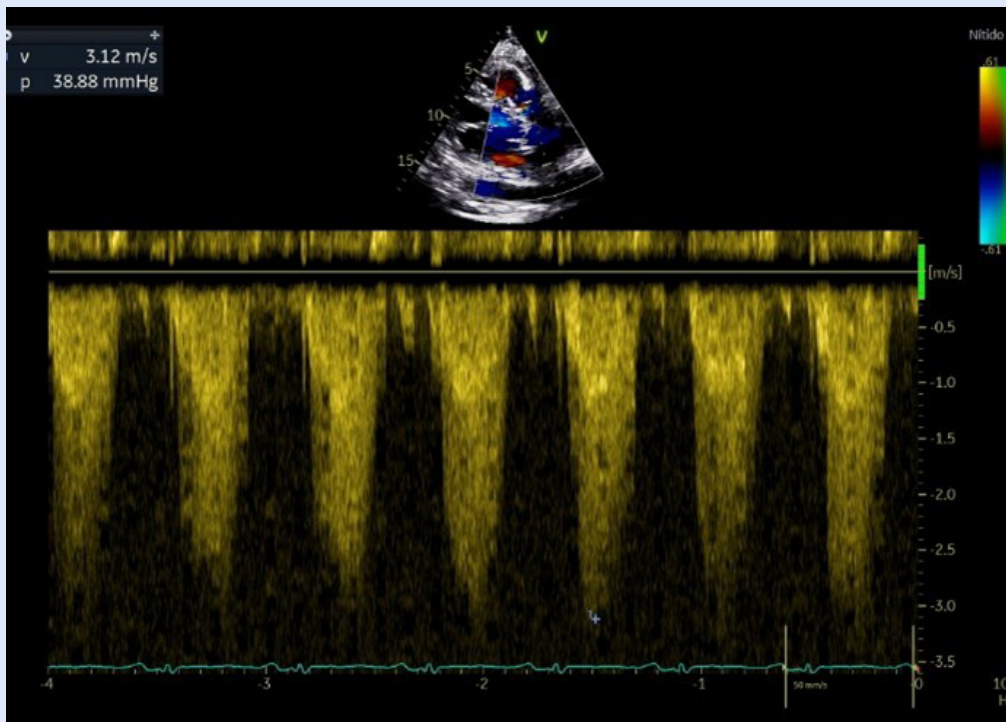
Supravalvular pulmonary stenosis on transthoracic echocardiography. Continuous-wave Doppler showed increased peak velocity and maximum gradient, consistent with pulmonary stenosis.
